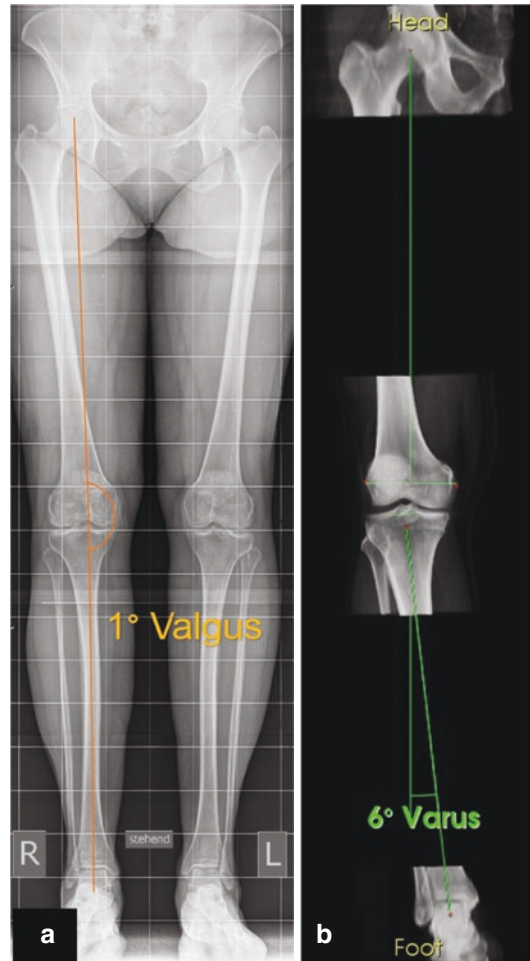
The influence of flexion and extension on a patient's lower limb alignment. The radiograph on the left side (a) shows the patient in standing position, the measured limb alignment is a valgus 1°. However, the 3D reconstructed model of the patient (b) shows a valgus alignment of 7°. This difference may be caused by an external rotation of the limb on the radiograph
